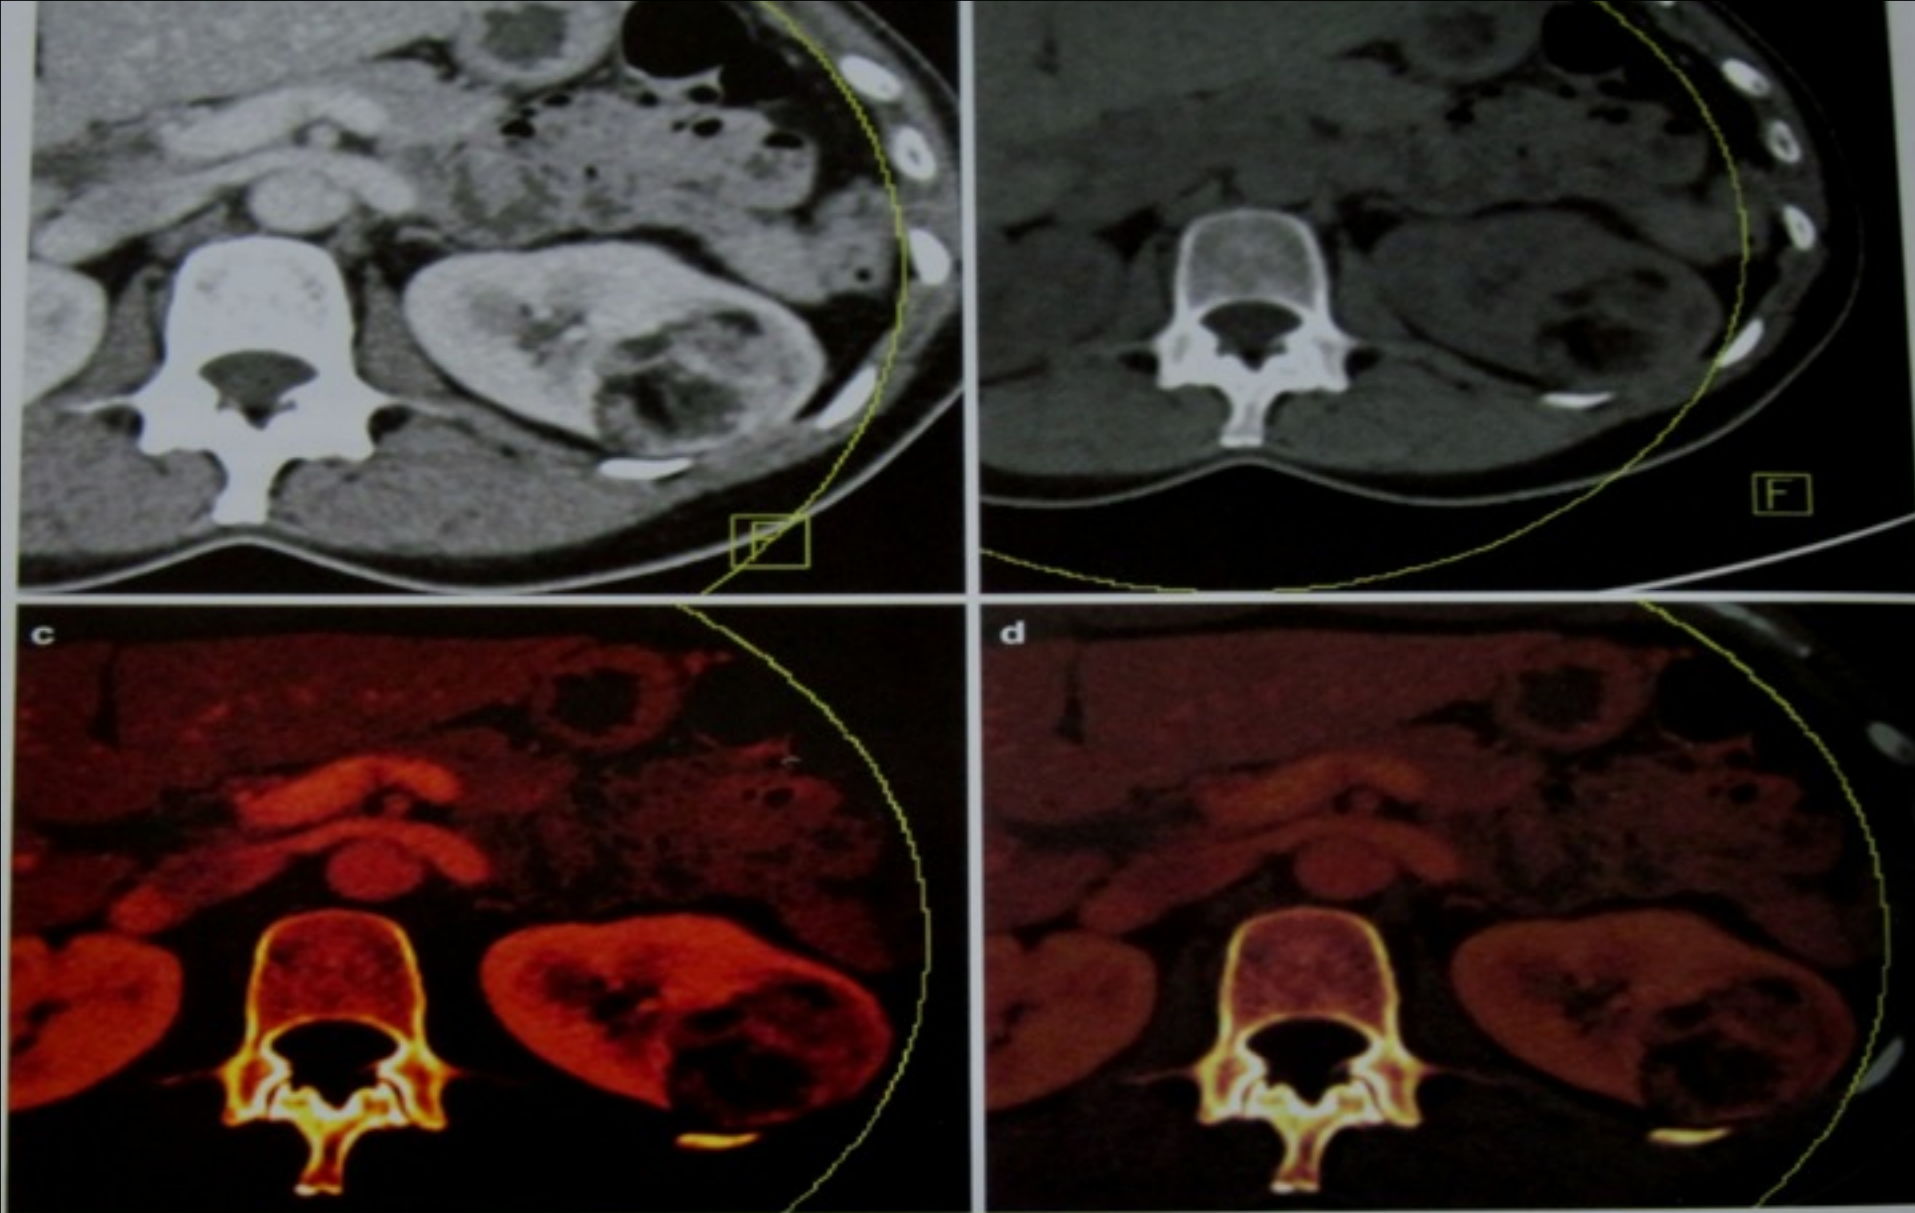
Hemorrhagic renal cyst. (A) Conventional contrast-enhanced CT shows an indeterminate left renal lesion (arrow). (B) DECT virtual unenhanced image shows that the lesion is hyperdense compared with adjacent renal parenchyma. (C) DECT iodine image with color overlay (iodine-containing structures are depicted with an orange-yellow hue) shows no iodine (ie, enhancement) in the lesion. (D) A conventional, true, precontrast image. (E) A magnetic resonance subtraction image. Note that DECT can, in a single acquisition (B-C), provide the same information as that obtained from 2 acquisitions (A, D). However, the iodine image (C) is not a "true" subtraction image because bone (eg, vertebral body, ribs) is present on both the virtual noncontrast (B) and iodine (C) displays.
